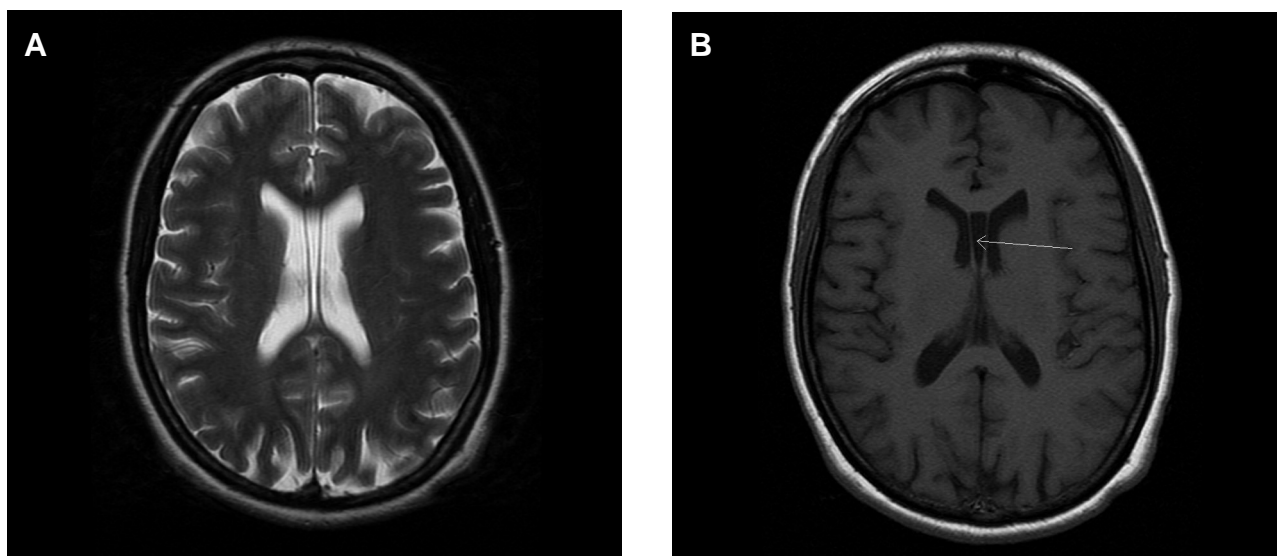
Images of axle cuts of T2 weighted MRI in T2 (left) and T1 (right). Observe the cavum septum pellucidum (see white arrow in the image on the right). To consider large-size CSP, it must be observed in cuts equivalent to 6 mm or more, depending on the inter-cut distance of the test.
